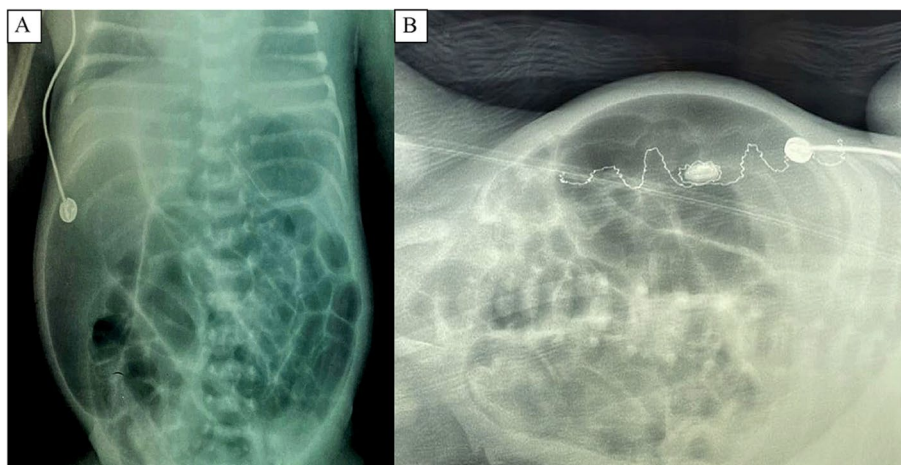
Abdominal radiograph (A in supine position) and (B in left lateral decubitus) shows focal bowel dilatation at the right sided abdomen overlapping with other bowel loops mimicking Rigler sign. No intramural air or portal venous gas
